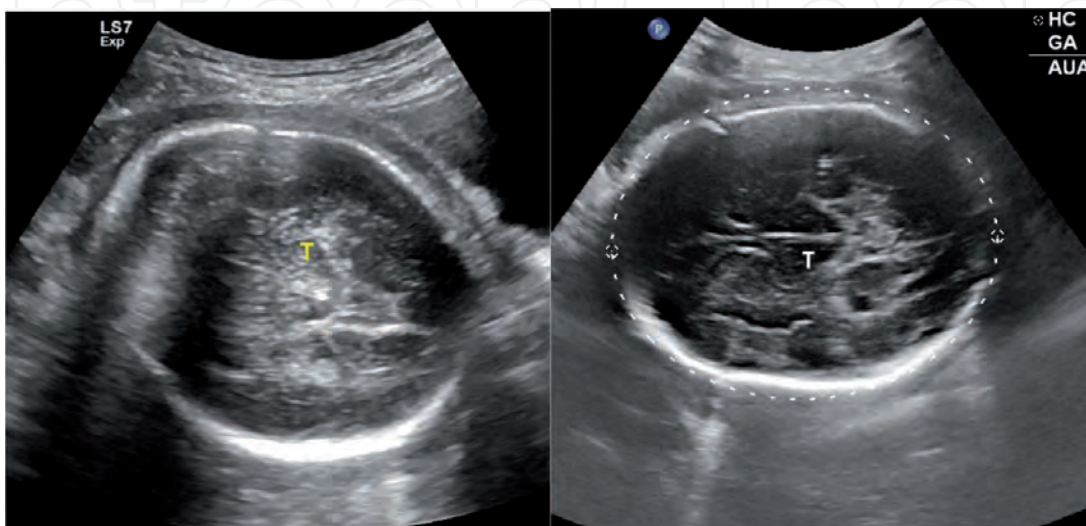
Obstetric ultrasound showing biometric measurements. Fetal head: Sonograms of the fetal head at the level of the thalami (T) showing measurement of the head circumference.
